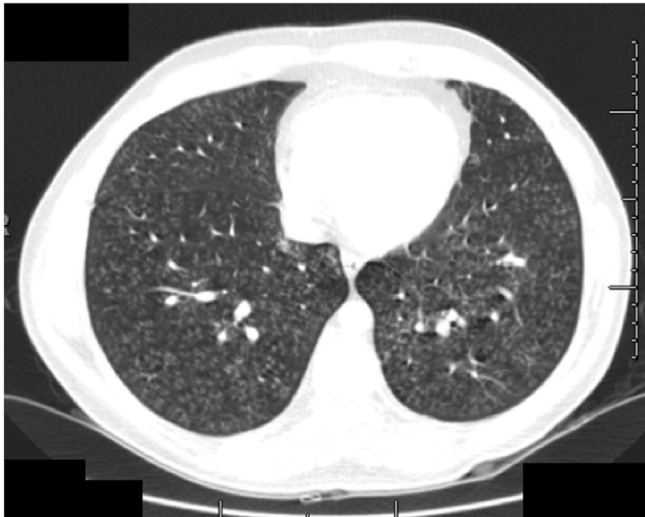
CT imaging taken at initial admission to the primary hospital. The image showed miliary opacities.
